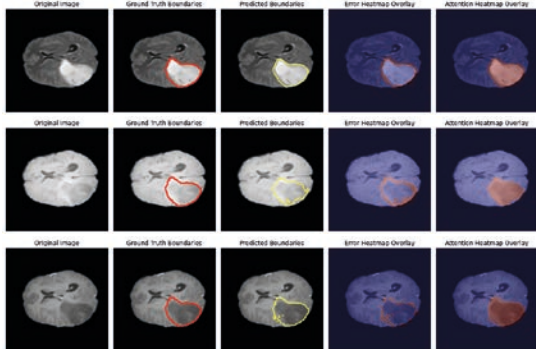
Segmentation examples for BraTS 2018 LGG: FLAIR, T1, T1CE, T2.
